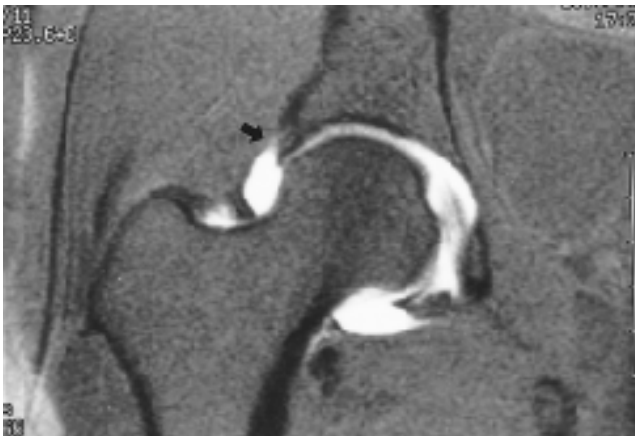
A 52-year-old female patient with chronic right hip pain. Coronal fat suppressed T1-weighted (666/16) image (direct MR arthrogram) shows triangular labrum with slightly increased signal intensity and intact labral recess at anterosuperior portion of the right hip (arrow). This case was proved stage IA at arthroscopically.
